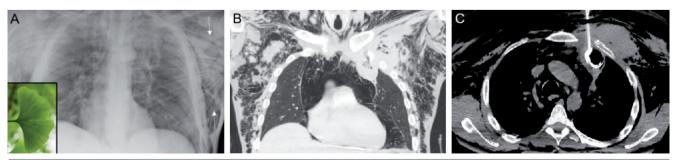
A) Chest X ray post-surgical wound exploration, demonstrating air(arrows) tracking along muscle fibers of pectoralis major muscle, akin to the "gingko leaf" (inset). B) Coronal reconstruction of Chest CT scan demonstrating extensive subcutaneous emphysema (arrow) and pneumo-mediastinum (star). C) Insertion of intercostal chest tube into cavity.
